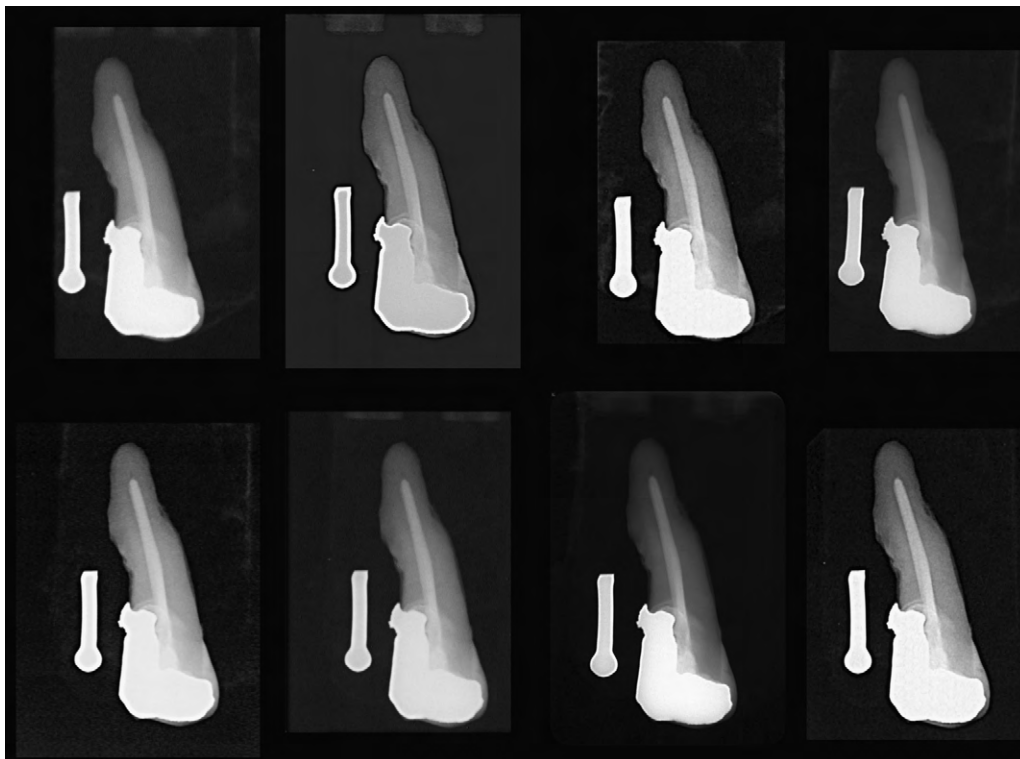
The observation screen of a premolar sample, comparing images taken by four X-ray devices (AnyRay[®], Nomad[®], Rextar[®], and MinRay[®]) with two image receptors (Dürr PSP[®] and Sigma[®] M CMOS). All images were scored using the 4-point rating scale (3–excellent, 2–good, 1–poor, and 0–very poor).
